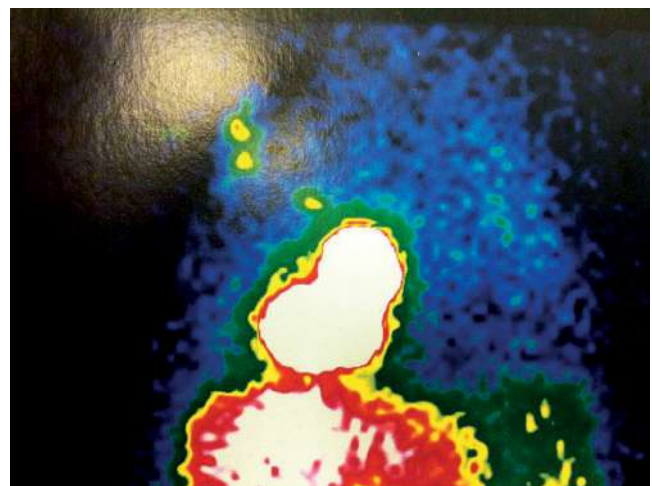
Lymphoscintigraphy with an intramammary sentinel lymph node and two axillary sentinel lymph nodes.
